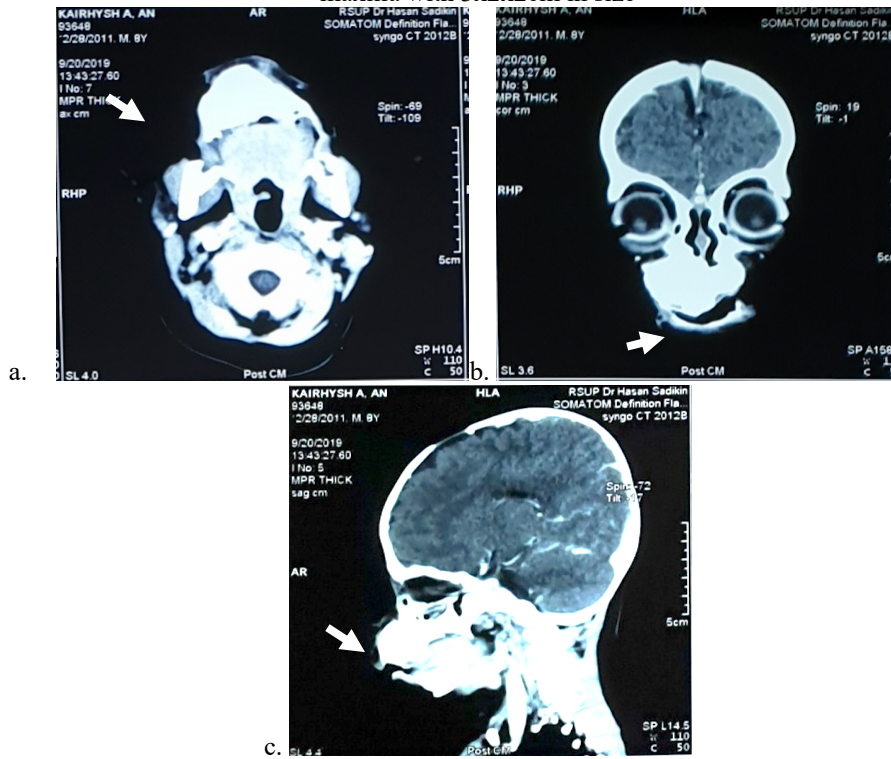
CT scan examination axial (a), coronal (b), and sagittal (c) view, a solid inhomogenic mass (white arrow) originating from maxilla, obliterating palate, right masticatory space, and infiltrate right maxillary sinus.
